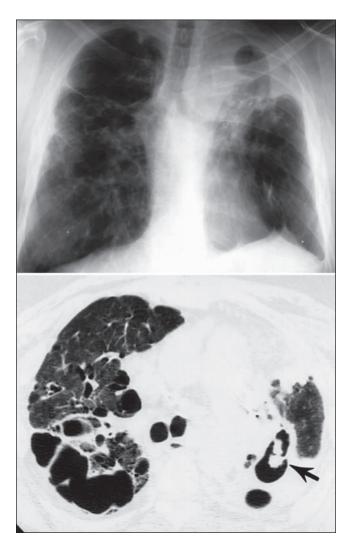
Top*: Stage IV sarcoidosis. Posteroanterior chest radiograph demonstrates extensive cystic, bullous, and fibrotic changes; upward retraction of the hilum; and extensive pleural thickening in the left apex. Note surgical clips on the left lung from a previous left upper lobe lobectomy for a mycetoma. *Bottom*: HRCT demonstrating a mycetoma (arrow) in the superior segment of the left lower lobe in the same patient as in Fig 17, *top*, 8 months after resection a left upper lobe mycetoma. Note the bullae and cystic changes in the remaining lung parenchyma.
